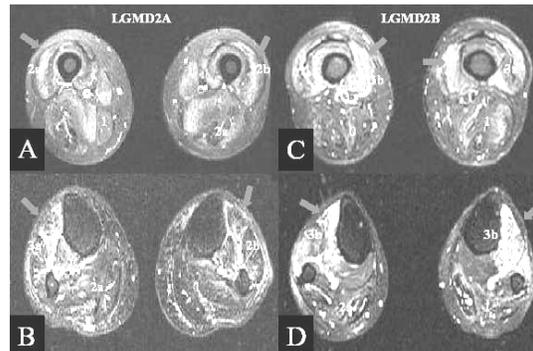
Evaluation of myoedema grade in lower limbs of LGMD2A and 2B patients, by using myoedema score on MRI (STIR sequences). Traverse slices of thigh (A) and leg (B) in patient affected by LGMD2A put in evidence (red arrow) an hyper-intense signal in the anterior compartments due to inflammatory myoedema. Traverse slices of thigh (C) and leg (D) in patient affected by LGMD2B show an hyper-intense signal (red arrow) in the anterior compartments due to inflammatory myoedema. The leg seems to be more involved than the thigh in both dystrophies.
